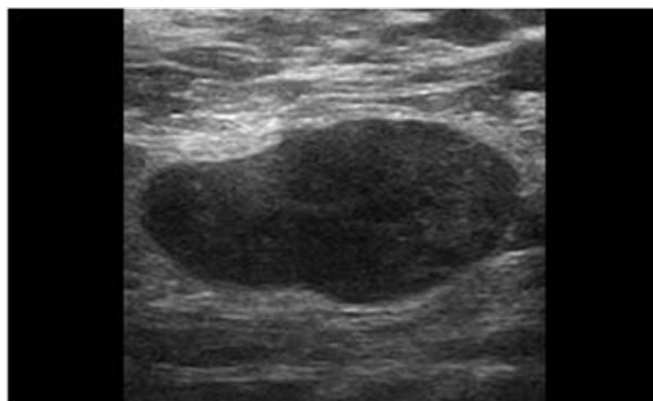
18F-FDG PET/CT and ultrasonographic demonstration of metastatic axillary lymphadenopathy Multiple FDG-avid bilateral axillary and deep pectoral lymph nodes are noted, with the largest measuring approximately 1.5×1.1 cm and demonstrating a SUVmax of 9.5. Ultrasonography demonstrates an enlarged necrotic lymph node in the left axilla. The combined metabolic and morphological findings are suggestive of metastatic axillary lymph-node involvement in a known case of left breast carcinoma.
